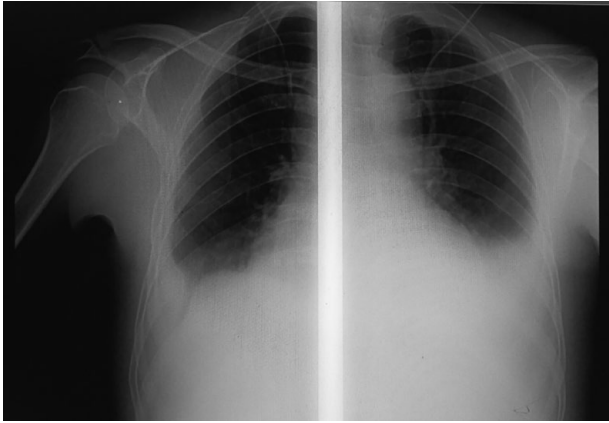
Chest-X-ray showing cardiomegaly with bilateral pleural effusion.
